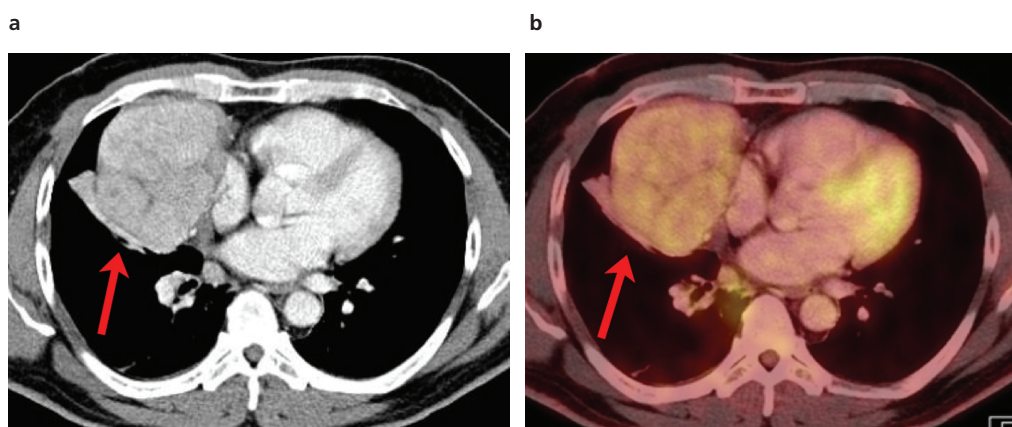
Non-Hodgkin lymphoma. Axial images. Prevascular mass with slightly heterogeneous enhancement on IV contrast-enhanced CT (a). PET-CT fusion imaging (B) shows mild hypermetabolism (SUV_{max} 4.2).
